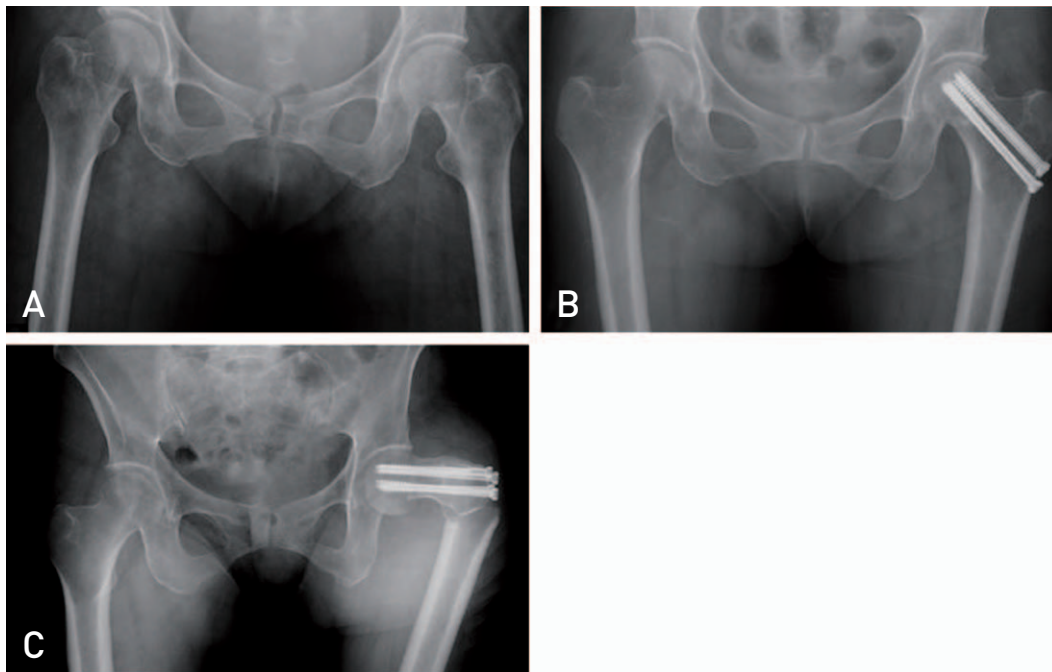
Seventy two-year-old female patient with valgus impacted right femoral neck fracture. (A) Preoperative plain film shows valgus impacted neck fracture in the left femur. (B) *In situ* internal fixation with 4 cannulated screws. (C) Four weeks after the operation, subtrochanteric fracture through the pin insertion site occurred after slip down.
